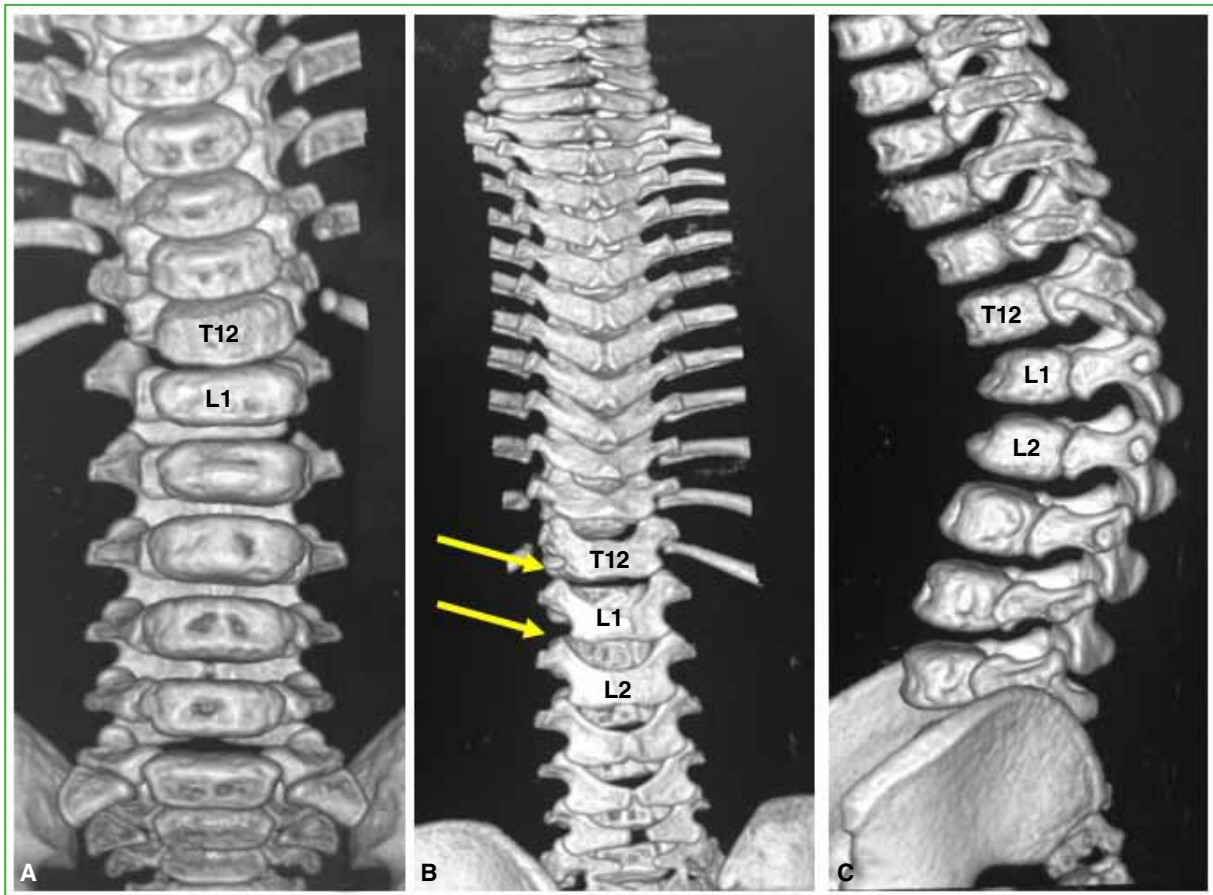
3D reconstruction by computed tomography. A. Note that compression fractures of the L1 and L2 vertebral bodies are asymmetrical. B. Right facet denudation (yellow arrows). C. Sagittal plane. Subluxation of T12-L1 and very low contact of T12-L1-L2 facets.
